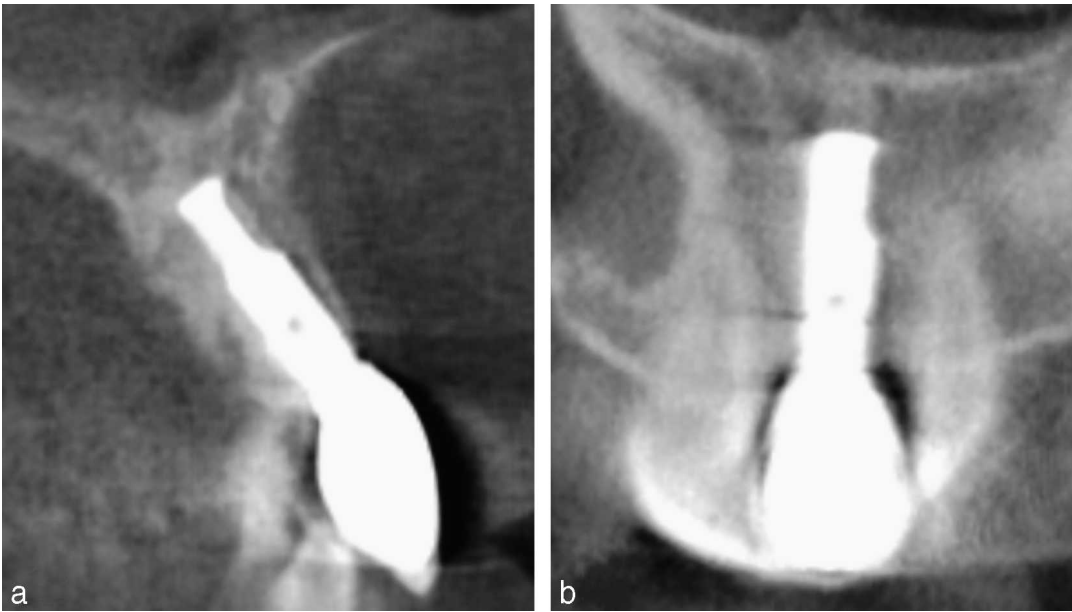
Reconstructed 2-dimensional cone-beam computed tomography (CBCT) images of a maxillary incisor implant. Two-dimensional images of the dental implant were reconstructed using OsiriX imaging software. (a) Narrow alveolar bone on the labial side was noted, and the labial bone thickness at the central superoinferior level of the implant was 1.7 mm. (b) An alveolar bone crest on the mesiodistal side of the dental implant was identified at the level of the implant neck.
